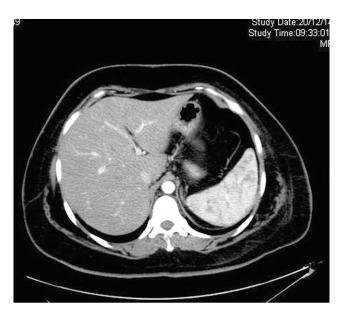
CT axial image of the liver at gastrohepatic level showing well defined and variably sized lymph nodes.
